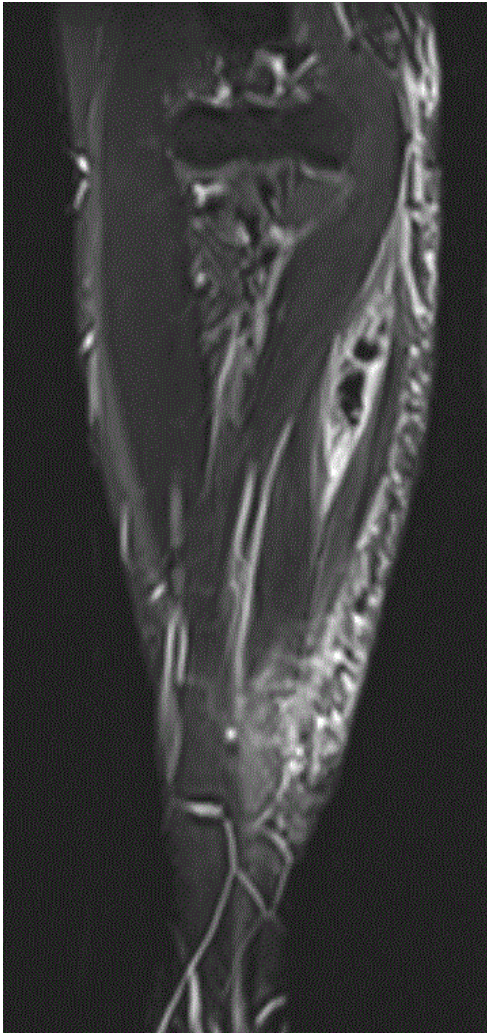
Coronal section of T2 MRI right forearm : Suspected rupture of flexor carpi radialis(FCR) tendon in seen with edematous change in subcutaneous tissue at posteromedial side of right elbow
